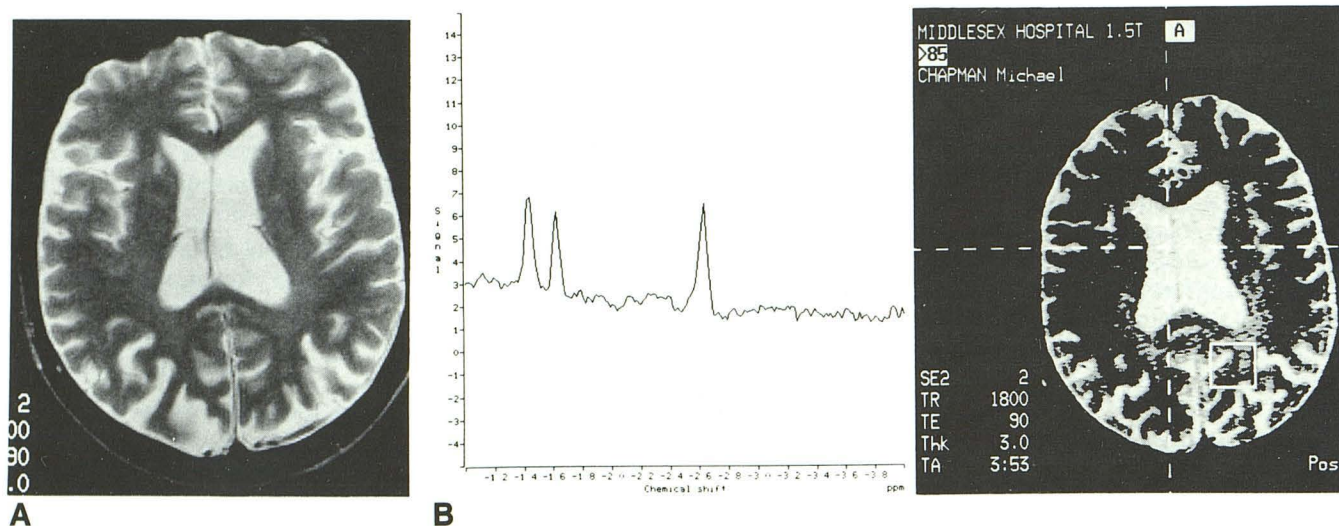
A, T2-weighted image (3500/90) of a 29-year-old patient with mild encephalopathic changes of diffuse white-matter disease and minimal cerebral atrophy.
